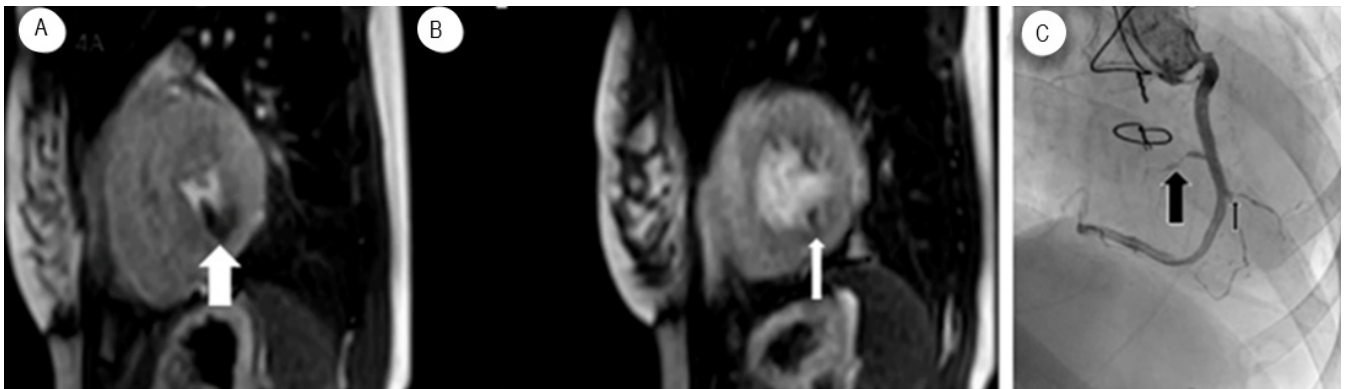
(A,B) MRI Perfusion images showing inferior ischemia induced by Adenosine (white arrow) in a patient with known CAV (C) Black arrows showing stenosis on selective coronary angiogram.
